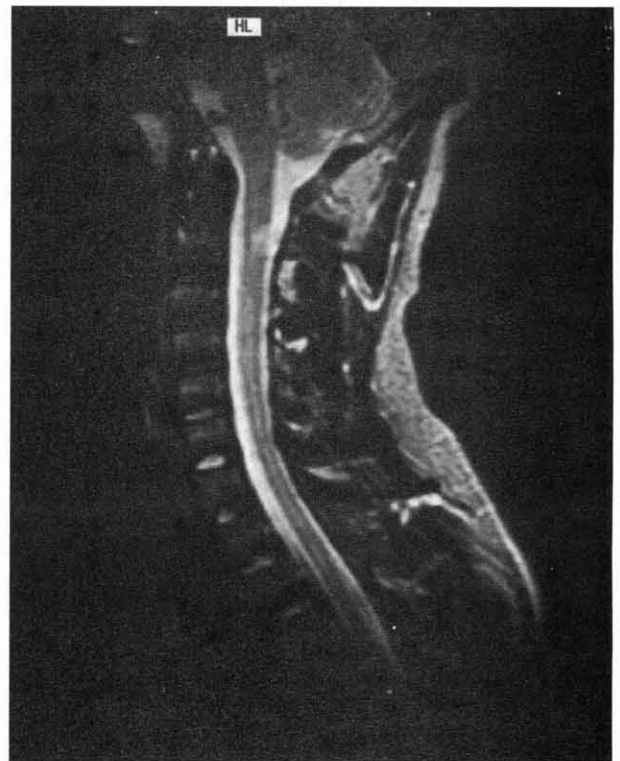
Plaques in cervical part of spinal cord (C2). T2-weighted image, sagittal plane.
